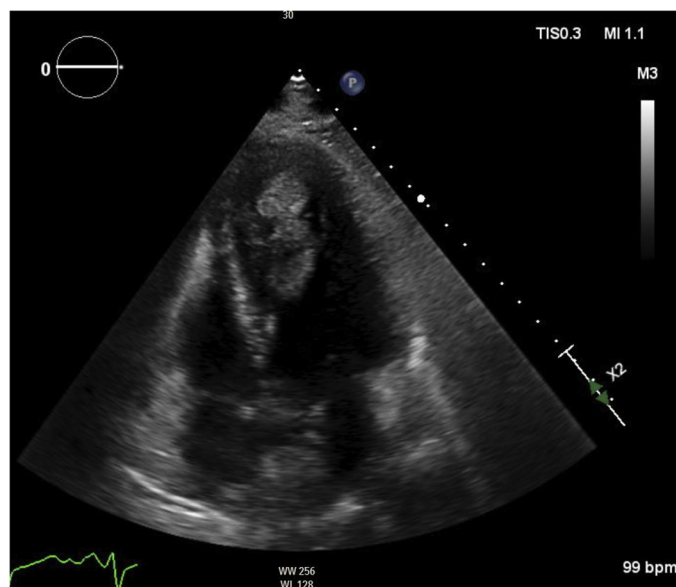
An echocardiographic image demonstrates a large left ventricular apical thrombus.
